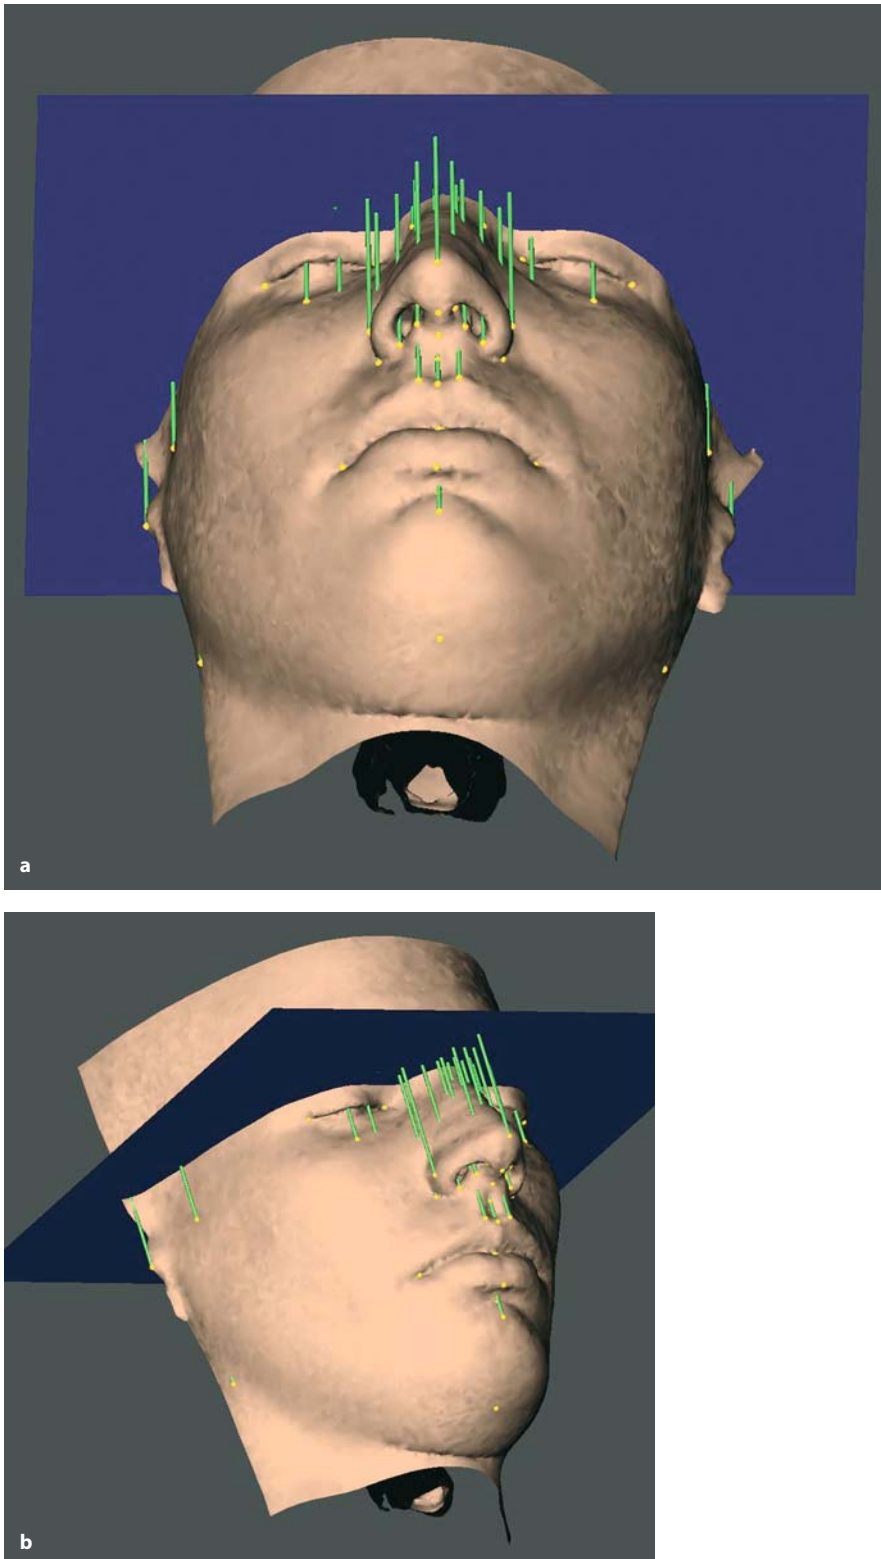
Set-up of vertical orthogonal soft tissue measurements to the x-plane (3-D CT, patient K.C.)
